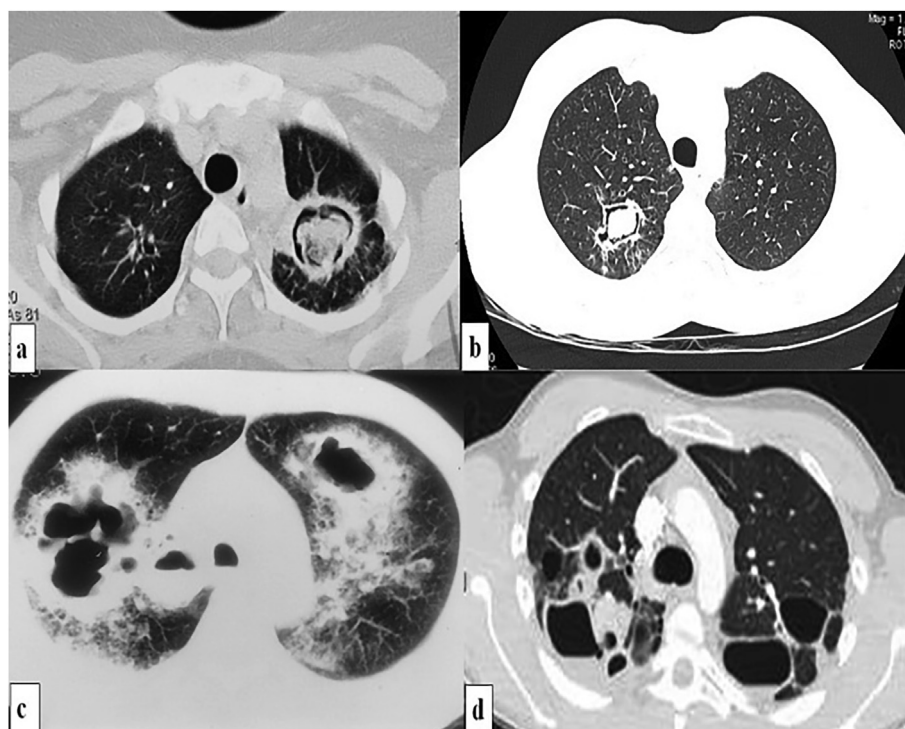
HRCT chest showing different pattern of aspergillosis radiology findings. a) Left upper lobe thick wall cavity in a case of aspergilloma. b) Right upper lobe thin wall cavity lesion in a case of CCPA. c) Bilateral thick wall cavity lesion with pericavitary infiltrate in a case of CFPA. d) Multiple cavity lesions of bilateral lung in a case of CCPA.
